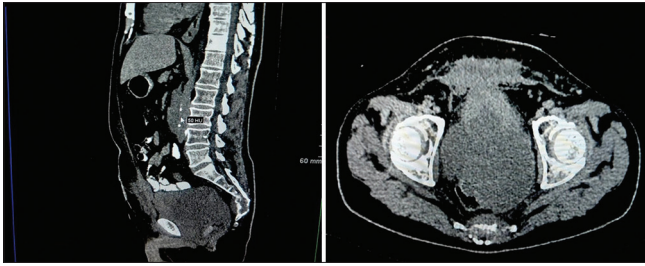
A computed tomography evaluation of the patient confirmed the presence of a vesicocutaneous fistula due to an infiltrating prostatic mass of 400 ml size running through the bladder wall toward the anterior abdominal wall. Large retroperitoneal lymph node masses were also evidenced in the computed tomography scan
